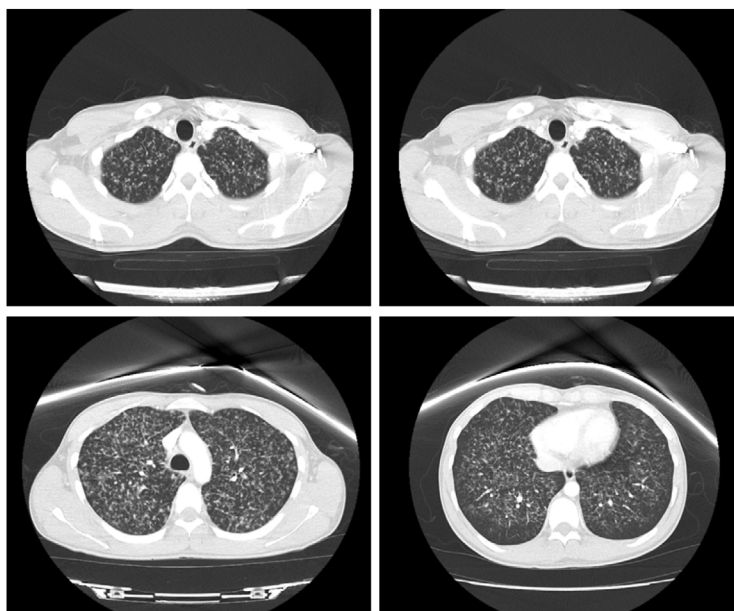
Chest computed tomography angiography with presence of *bilateral diffuse* micronodular interstitial pattern.
